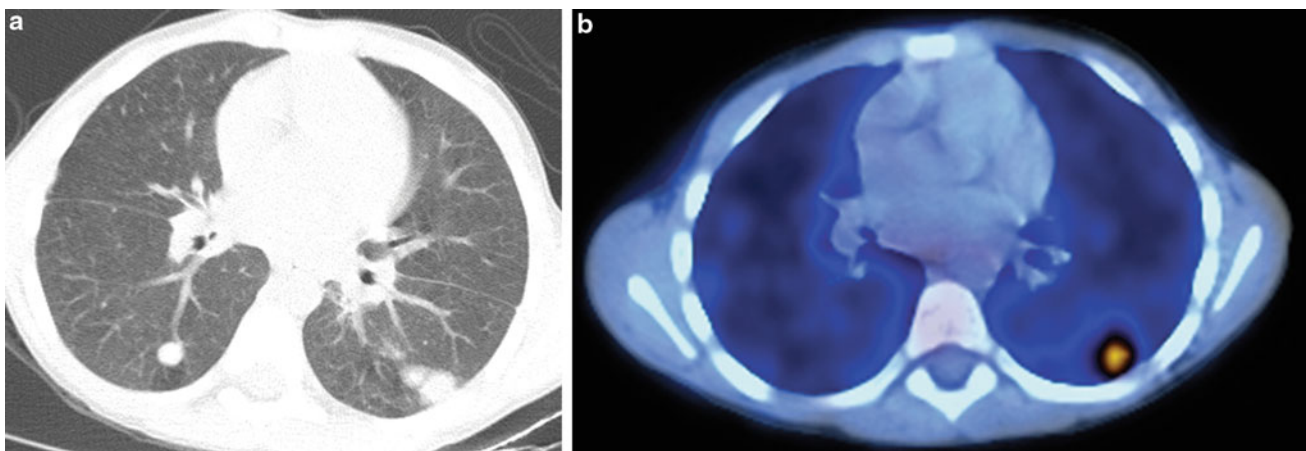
Chronic granulomatous disease (CGD). An axial chest CT image (a) in a 6-year old undergoing evaluation for bone marrow transplantation for CGD shows multiple bilateral pulmonary nodules. An axial fused FDG-PET/CT image (b) reveals increased FDG uptake
